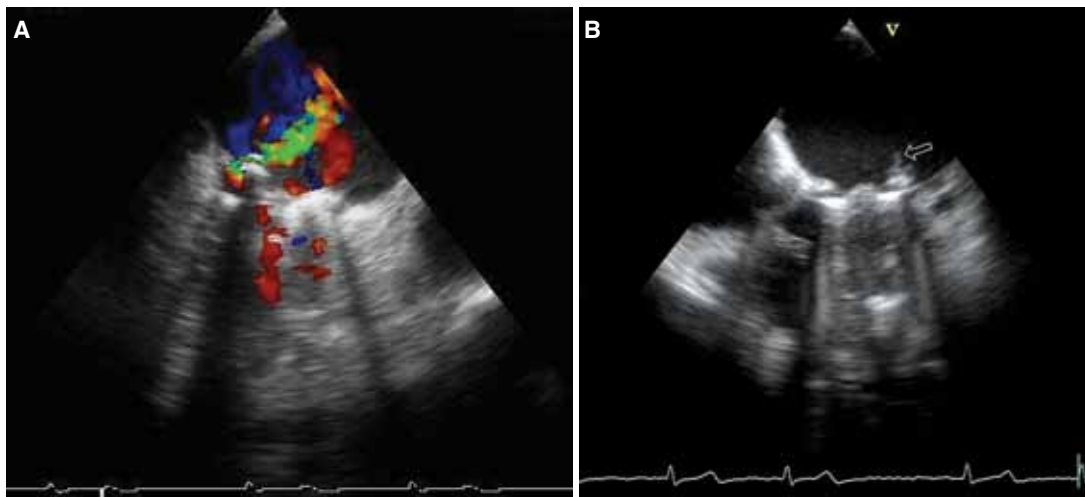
Transesophageal echocardiograms showing (A) lateral periprosthetic mitral regurgitation and (B) a large vegetation on the mitral valve.
